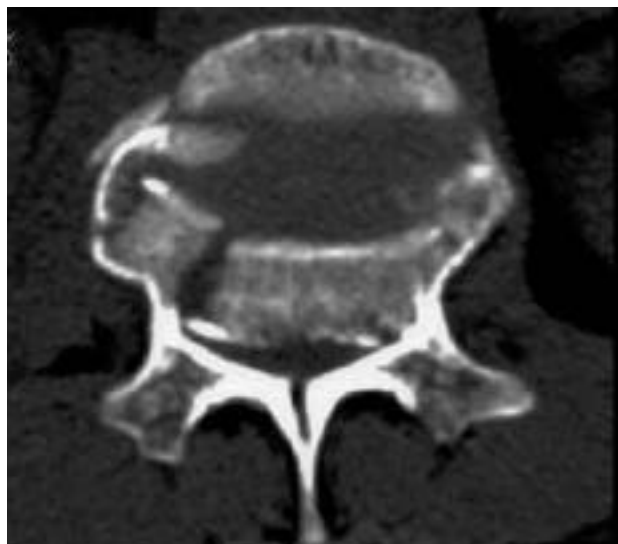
The CT image shows over 60% encroachment of spinal canal and laminar fracture.
